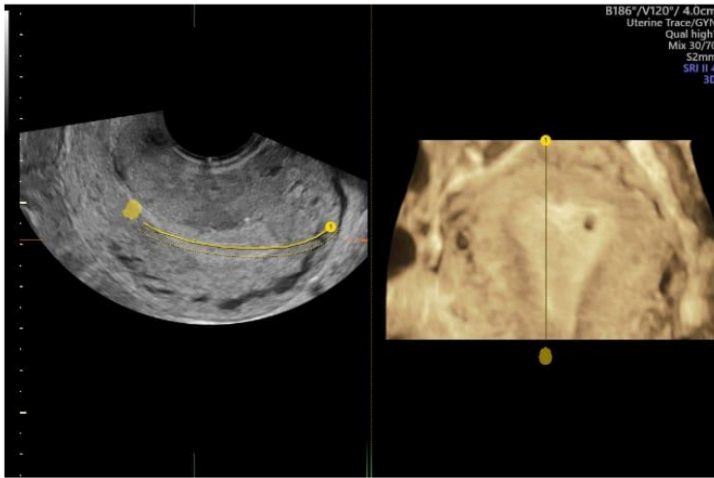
3D ultrasound images showing the presence of a left cornual ectopic pregnancy with an empty uterine cavity.
